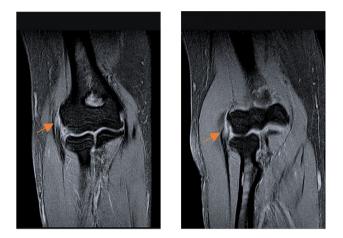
MRI fat suppressed axial frames showing hypersignal in the common origin the common origin of the extensor tendons (orange arrow)
